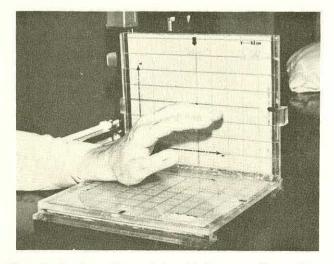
Hand positioned for biplanar radiographs.
